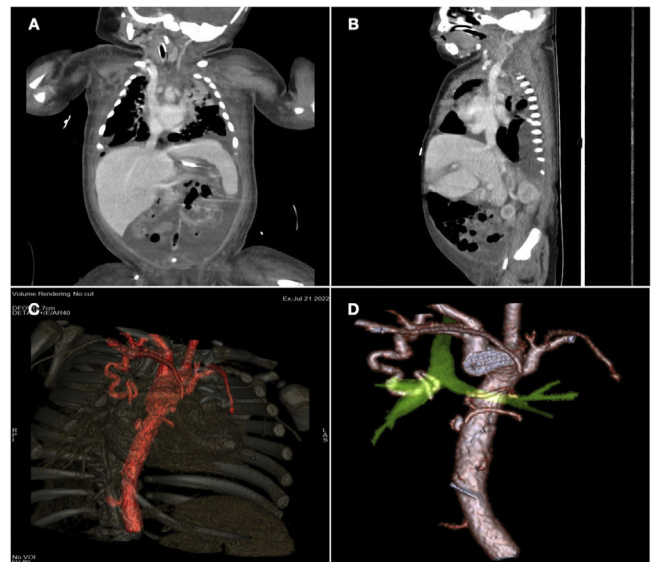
Computed tomography images. (A and B). Thrombosis of the left jugular-subclavian system. (C and D) Aberrant right bronchial artery originating from the right subclavian artery.
